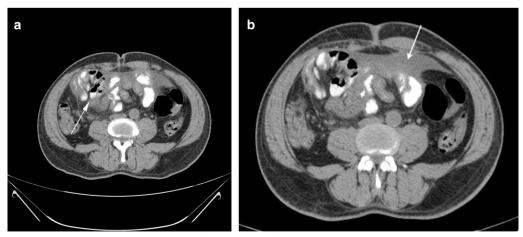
a Follow-up non-contrast CT axial section on day 4 of presentation after oral contrast administration shows near complete resolution of small bowel loop dilatation in right iliac fossa (annotated by white arrow) following conservative management with ATT and supportive therapy. Smooth transit of oral contrast is noted through non-dilated clumped-up bowel loops. b Follow-up non-contrast CT axial section also exhibited moderate ascites (annotated by white arrow)
